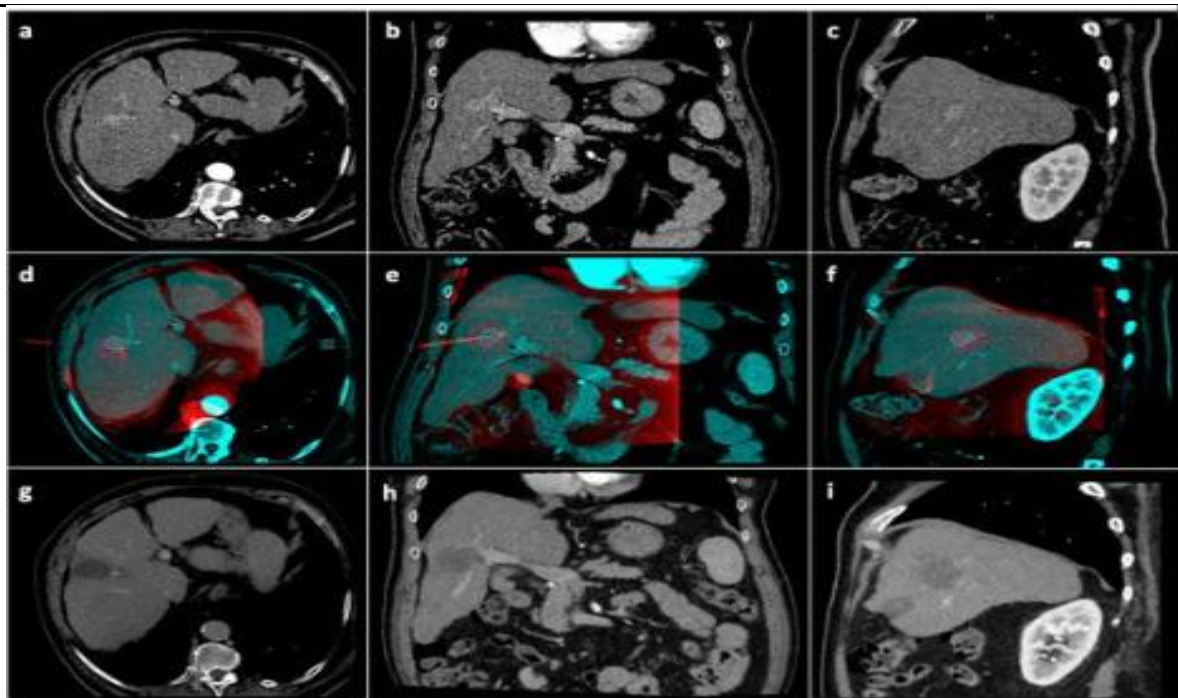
To identify tumor regions, to estimate ablation volume and to evaluate the outcomes after treatment. These are preprocedural CT coronal(b), CT sagittal(c), CT axial (a) planes of arterial phase pictures. Intraprocedural fusion image that shows the combination of pre- and intra-procedural CT scans of the tumor (blue) and the microwave antenna location (red), in the axial(d), coronal(e), and sagittal planes(f). Ablation power and time with the antenna location are used to create the virtual anticipated ablation volume (purple) including the tumor volume (blue line) with a 5 mm safety margin (green line).in the combined pictures. Axial (g), coronal (h), and sagittal (i) CT scans in the following month show complete resolution. [16].
